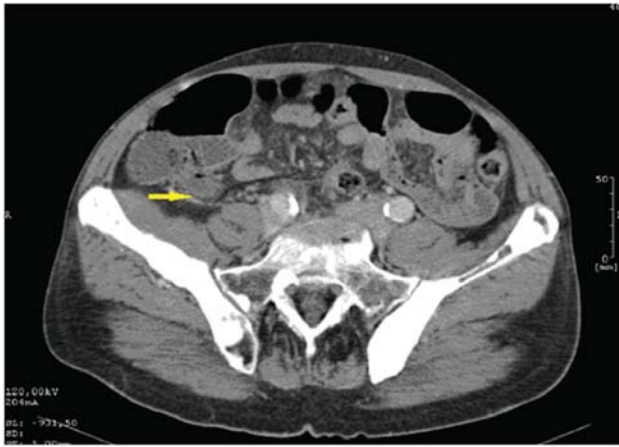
Abdominal computed tomography showing distended appendix, measuring 11 mm in diameter and diffuse infiltration of surrounding fat.
